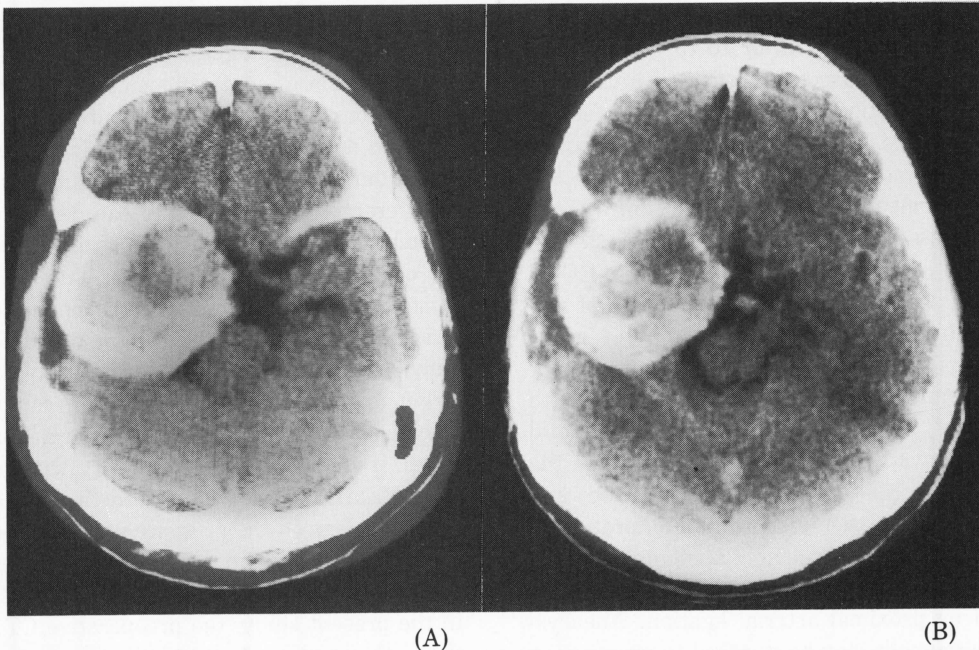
CT scans after complete closure of the cervical ICA in Case 2. A plain CT scan 18 days after occlusion shows the density of the eccentric area is slightly increased, indicating that the lumen is thrombosed (A). A post-contrast CT scan 4 months after complete occlusion demonstrates that the attenuation values of the eccentric round part and the peripheral zone decreased with time (B).
